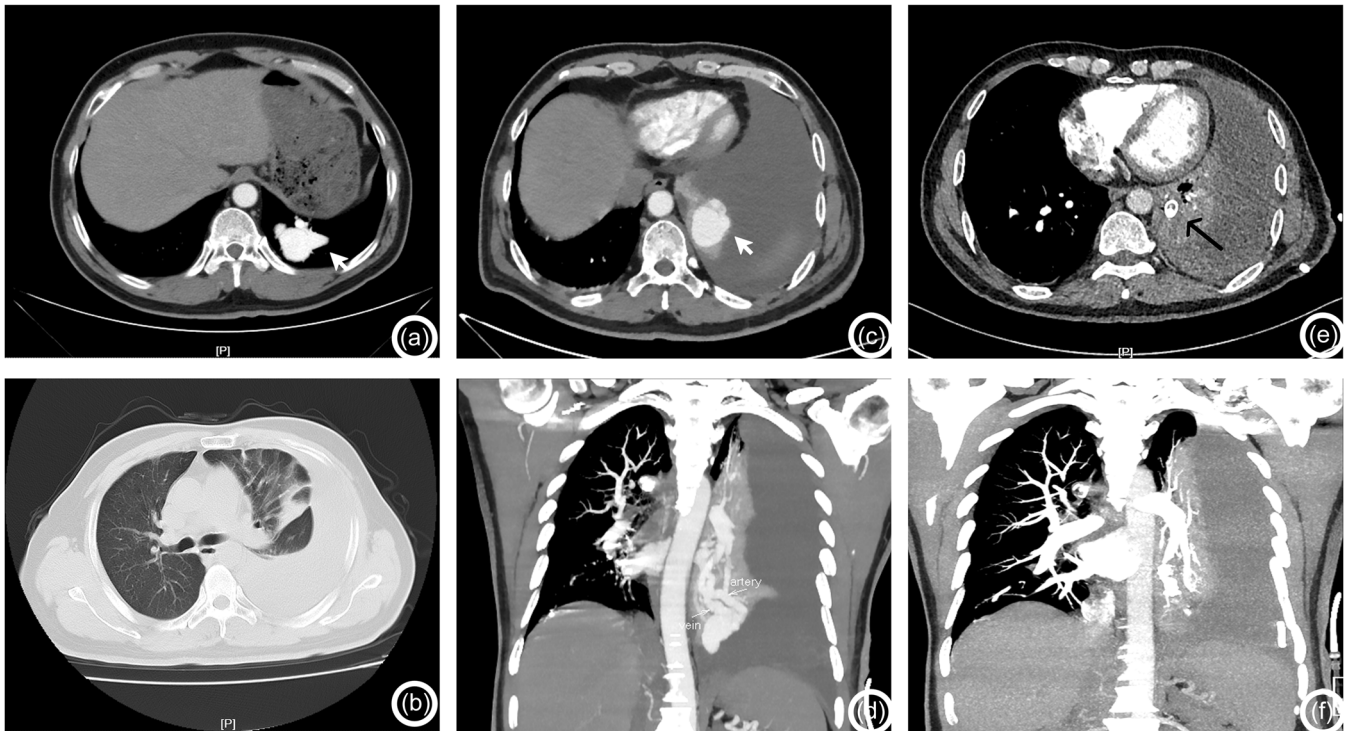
Patients' computed tomography images during hospitalization. (a) Patient underwent contrast-enhanced CT scans of the abdomen, revealing tortuous vascular shadows in the lower lobe of the left lung, indicative of pulmonary arteriovenous fistula; (b) chest CT was performed following admission, exposing significant fluid accumulation in the thoracic cavities, compressing the pulmonary tissue and promoting atelectasis; (c) (axial image), (d) (coronal image): CTA of pulmonary vessels delineated a tortuous course of the pulmonary artery in the lower lobe of the left lung, with luminal thickening, and a restricted contrast shadow measuring approximately 3.9×3.1 cm was visualized in the lower lobe of the left lung, communicating with the thickened pulmonary artery in the lower lobe of the left lung. Additionally, a prominent draining vein was observed, which converged into the left lower pulmonary vein; (e) (axial image), (f) (coronal image): Patient's CTA of the pulmonary artery was reviewed after interventional embolization, revealing a very dense visualisation of the spring coils, as presented in E.1.
